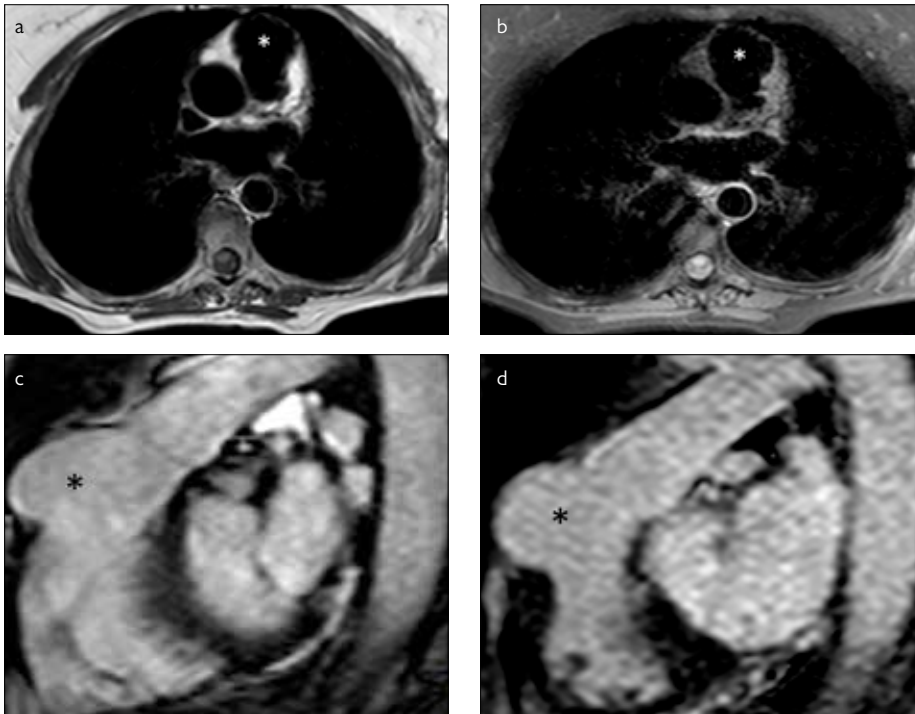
a-d. Axial T1-weighted (SEEP) image (a) and axial fat sat T2-weighted (SEEP) image (b) show the RVOT aneurysm (white asterisks). Sagittal T1-weighted contrast enhanced images (c, d) show the RVOT aneurysm (black asterisks). SEEP: Spin echo eco planar imaging. RVOT: Right ventricle outflow tract.
